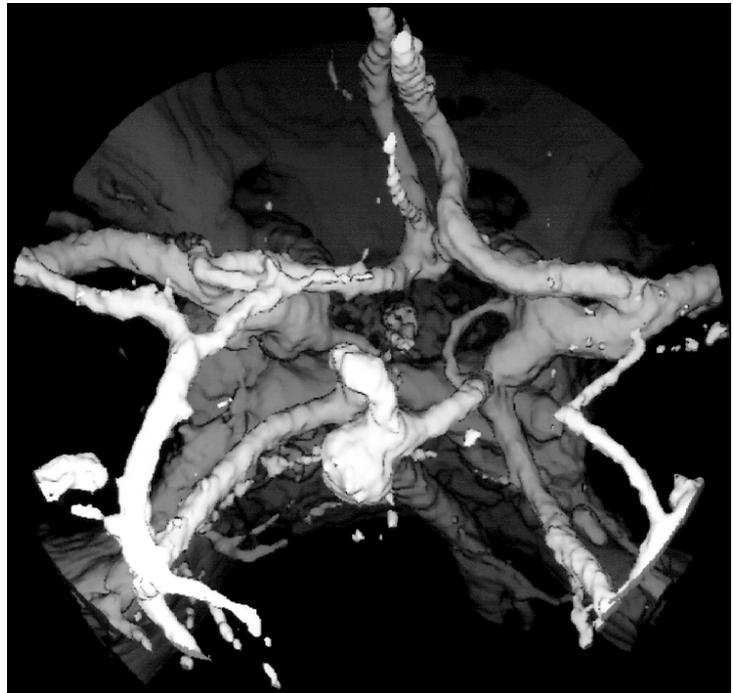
3D CTA of multiple aneurysms.
